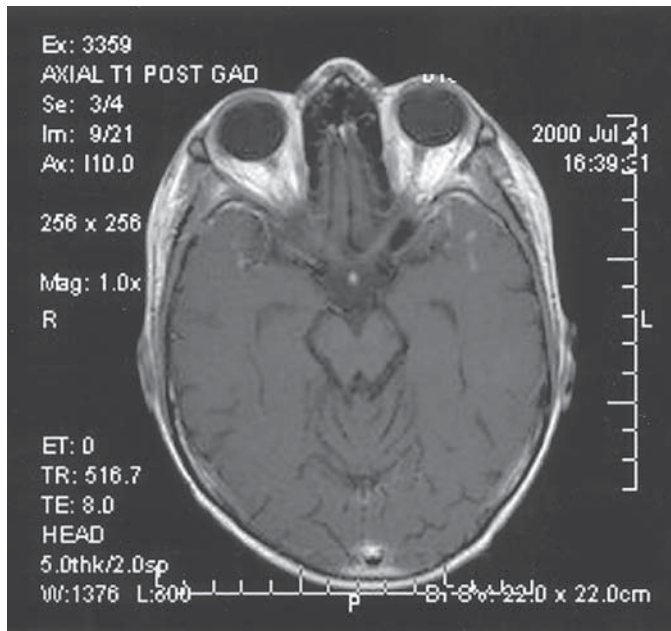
A T1-weighted MR scan with gadolinium contrast discloses abnormal enhancement of the meninges in both anterior temporal lobes. This patient received neuraxis radiotherapy and adjuvant chemotherapy for a medulloblastoma before developing patchy leptomeningeal metastases 4 yr after initial treatment.
